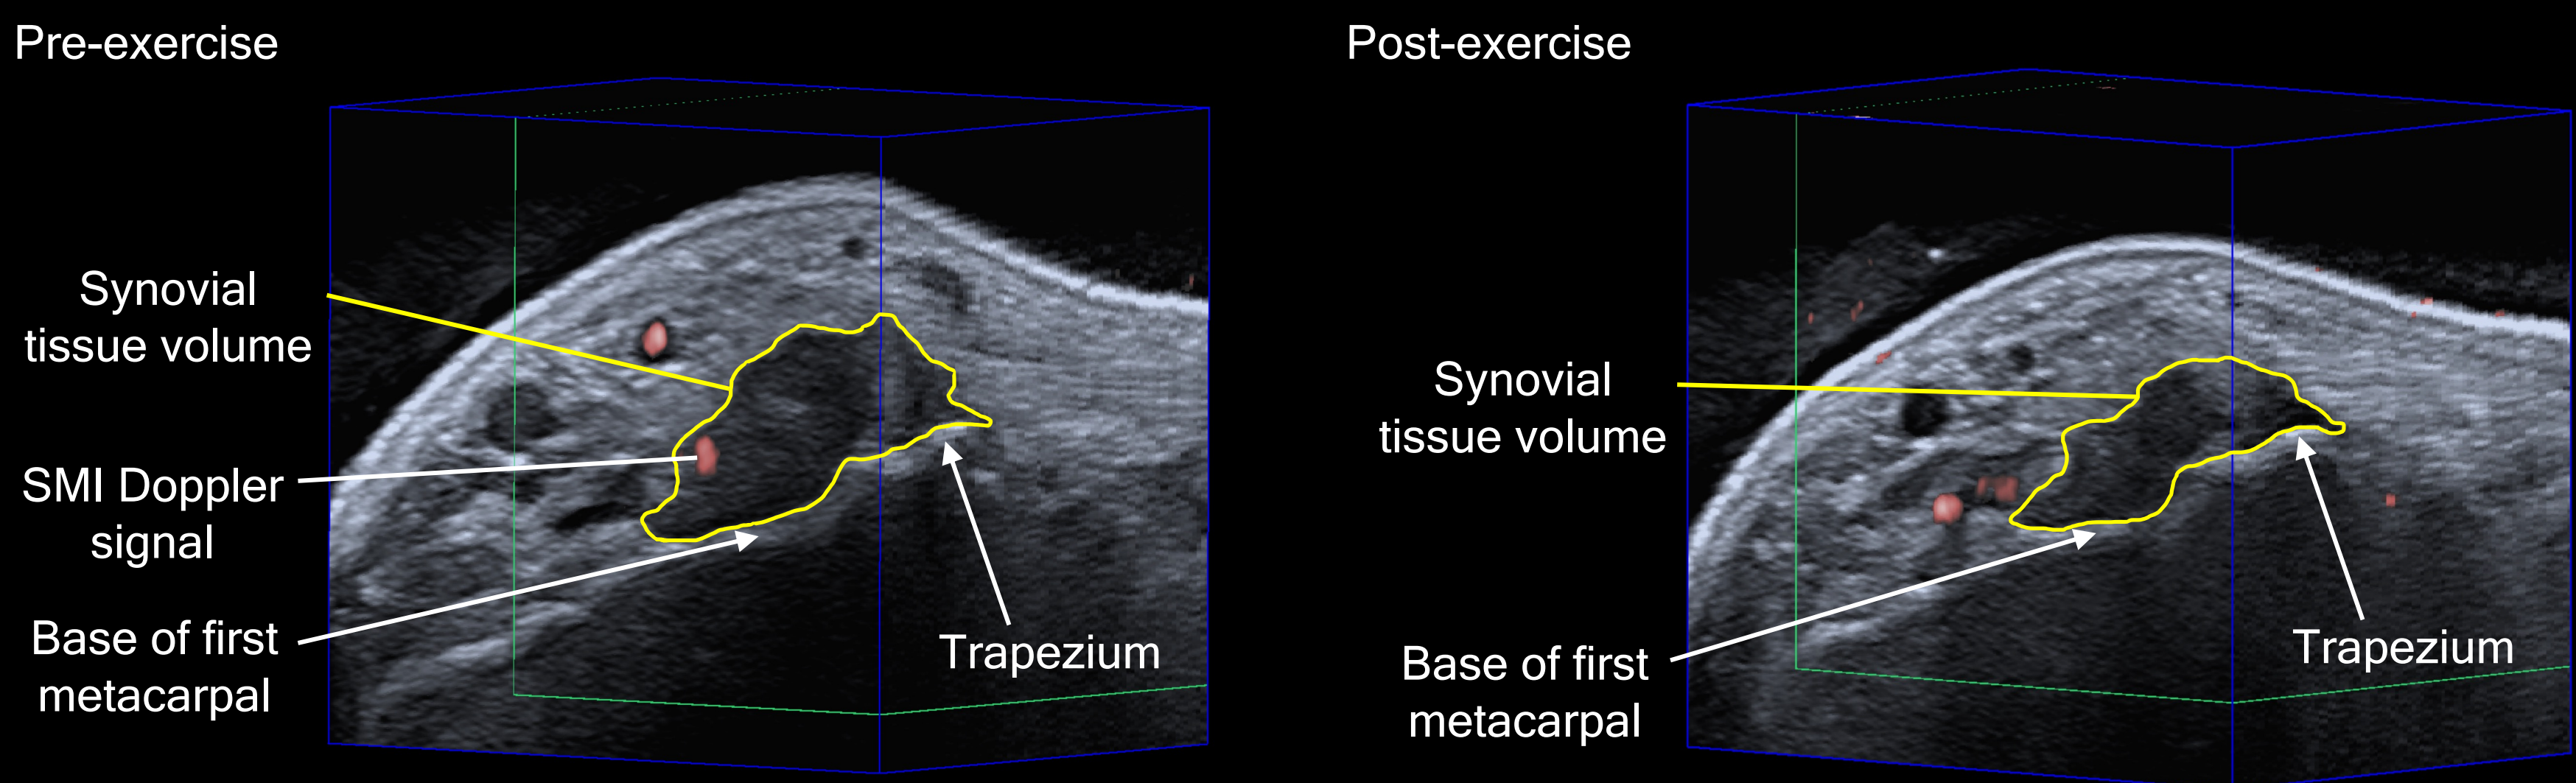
3D US Doppler images of thumb OA patient pre- and post-resistance thumb exercises. Doppler signals are shown as red voxels in the 3D image and the region of synovial tissue volume is outlined in yellow.
